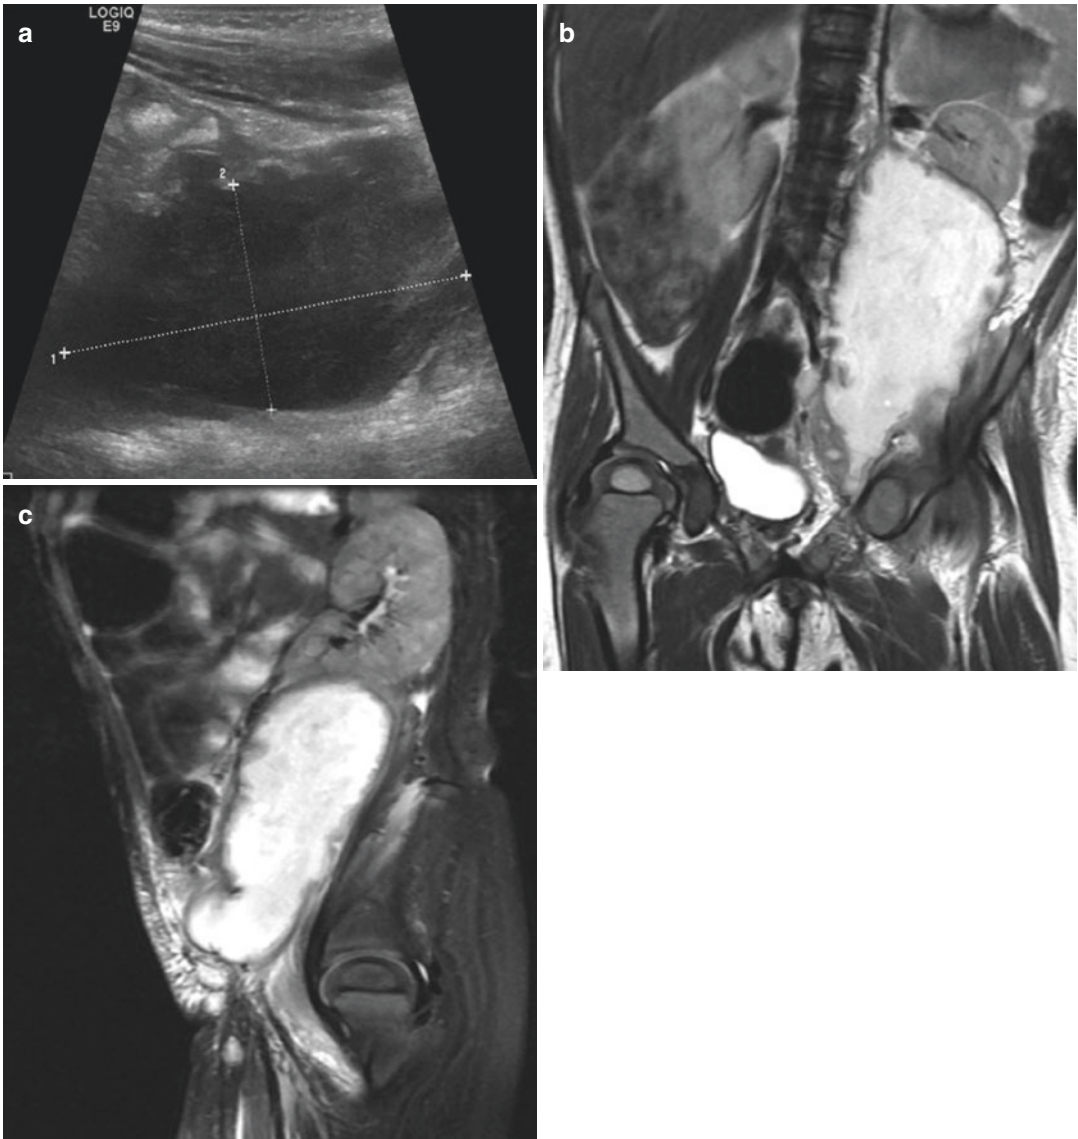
Psoas-iliac abscess in a 2-year-old girl with acute abdominal symptoms (its origin could not be defined). (a) US—Sagittal scan of the left flank demonstrates a large oblong hypoechoic mass. The technique was not able to define its exact location. (b) MR imaging T2-weighted sequence—Frontal view—Inverted pyramidal collection below the left kidney with inflammatory
